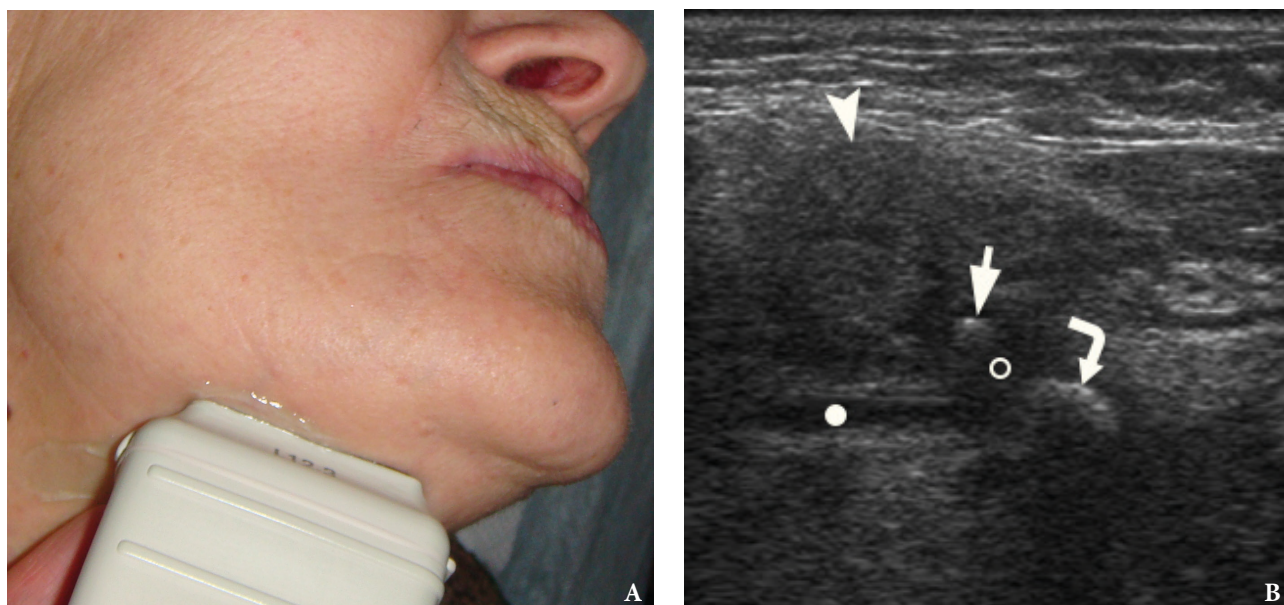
A 78-year-old woman with symptoms of acute obstructive submandibular sialadenitis. Linear probe placed in a position (A) for US examination of the right sublingual gland (*arrowhead*). Gray scale sonogram (B) shows dilated Wharton's duct (*white dot*), small sialolith (*arrow*) within the significantly dilated Bartholin's duct (*circle*), and bigger stone (*curved arrow*) in a place where the major duct of sublingual gland joins the duct of the submandibular gland. Acoustic shadowing noted behind each calculus.
